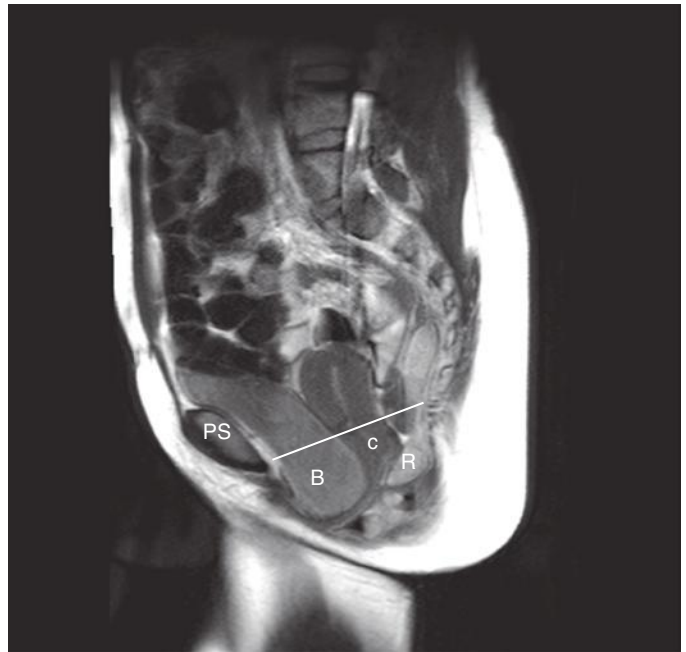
Cystocele on sagittal strain magnetic resonance image. Sagittal T2-weighted image of the pelvis during strain demonstrates anterior compartment descent of the urinary bladder (B) below the pubococcygeal line (white line) with some apical component as noted by partial descent of the uterus and cervix (c). PS, pubic symphysis; R, rectum.
